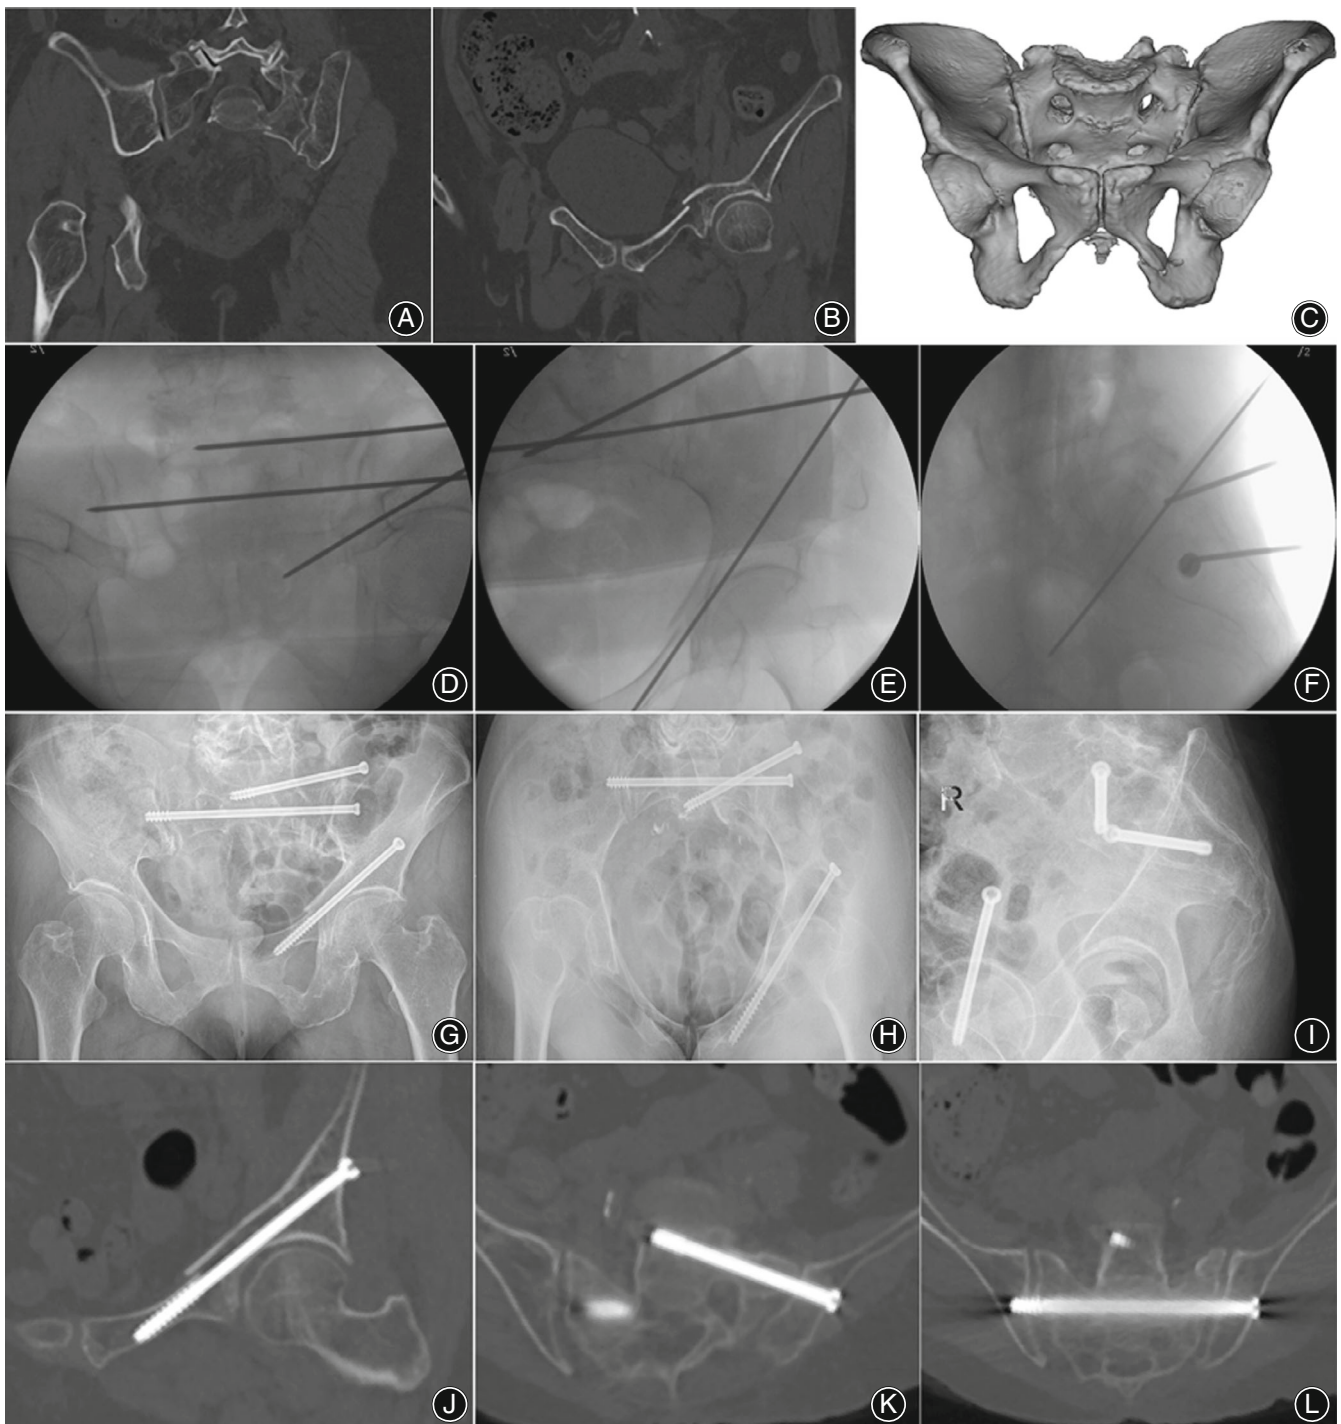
A 62-year-old patient, left sacral fracture (zone II) and pubic fracture (zone I). (A) Axial CT image showing a fracture of the sacrum zone II. (B) coronal CT image showing a fracture of the pubic zone I. (C) 3D reconstruction of the pelvis. (D–F) K-wires were inserted under assistance of the navigation template during the operation and C-arm fluoroscopy confirmed none of the K wires breached the cortex. (G) post-operation X-ray of pelvic in outlet view. (H) post-operation X-ray of pelvic in inlet view. (I) post-operation X-ray of pelvic in lateral view. (J) post-operation CT image of transpubic screw. (K) post-operation CT image of S1 screw. (L) post-operation CT image of S2 screw
